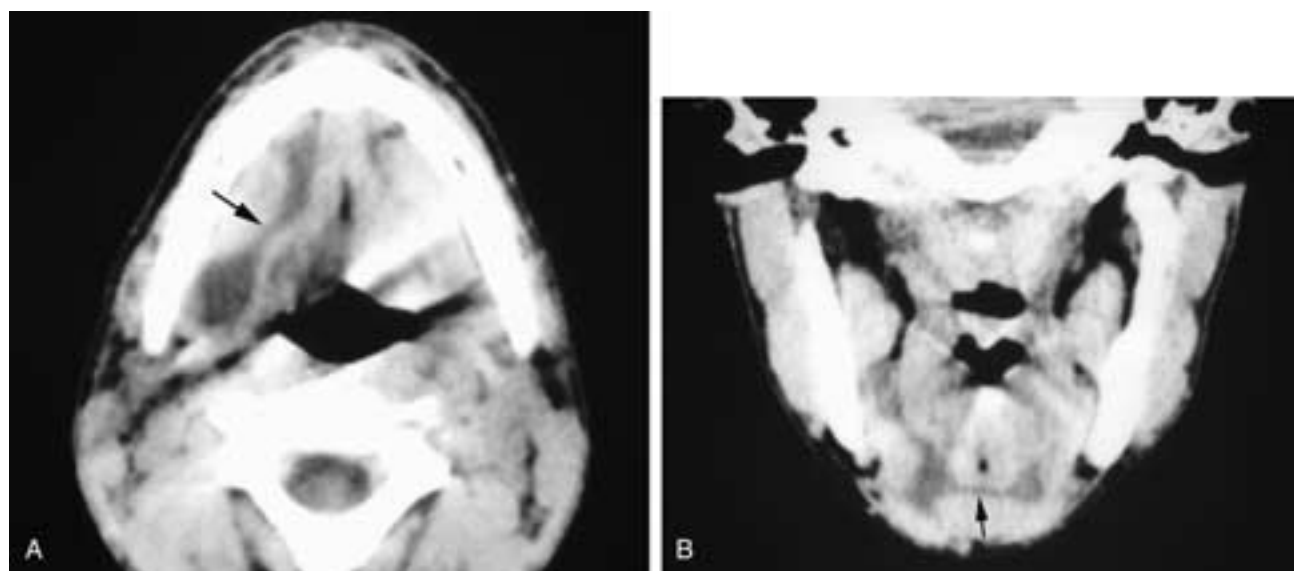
Axial (A) and coronal (B) CT scans show a low-attenuation (mucoid) collection (*arrows*) in the right floor of the mouth that has tracked down and across the midline floor of the mouth to the left side. This patient had a plunging ranula.
